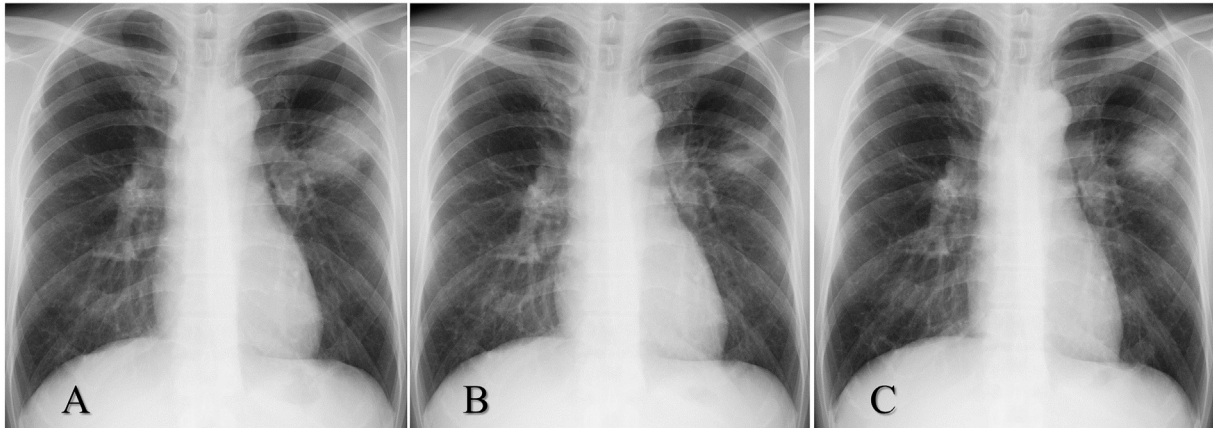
Radiological course. (A) Chest X-ray obtained 4 months before transfer to our hospital showed infiltration in the left upper-middle lung. (B) Two months later, although the infiltration on his X-ray had gotten better, it did not continue to improve. (C) Two months after this, the infiltration had re-expanded on transfer to our hospital.
